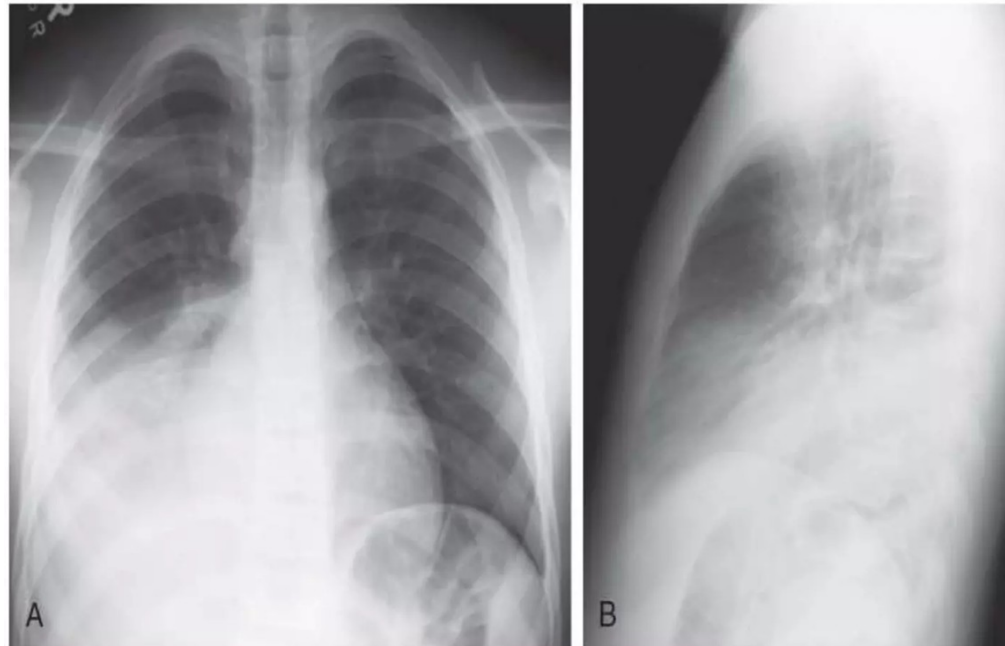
Radiographic findings characteristic of pneumococcal pneumonia in a 14 yr old boy with cough and fever. Posteroanterior (A) and lateral (B) chest radiographs reveal consolidation in the right lower lobe, strongly suggesting bacterial pneumonia.
